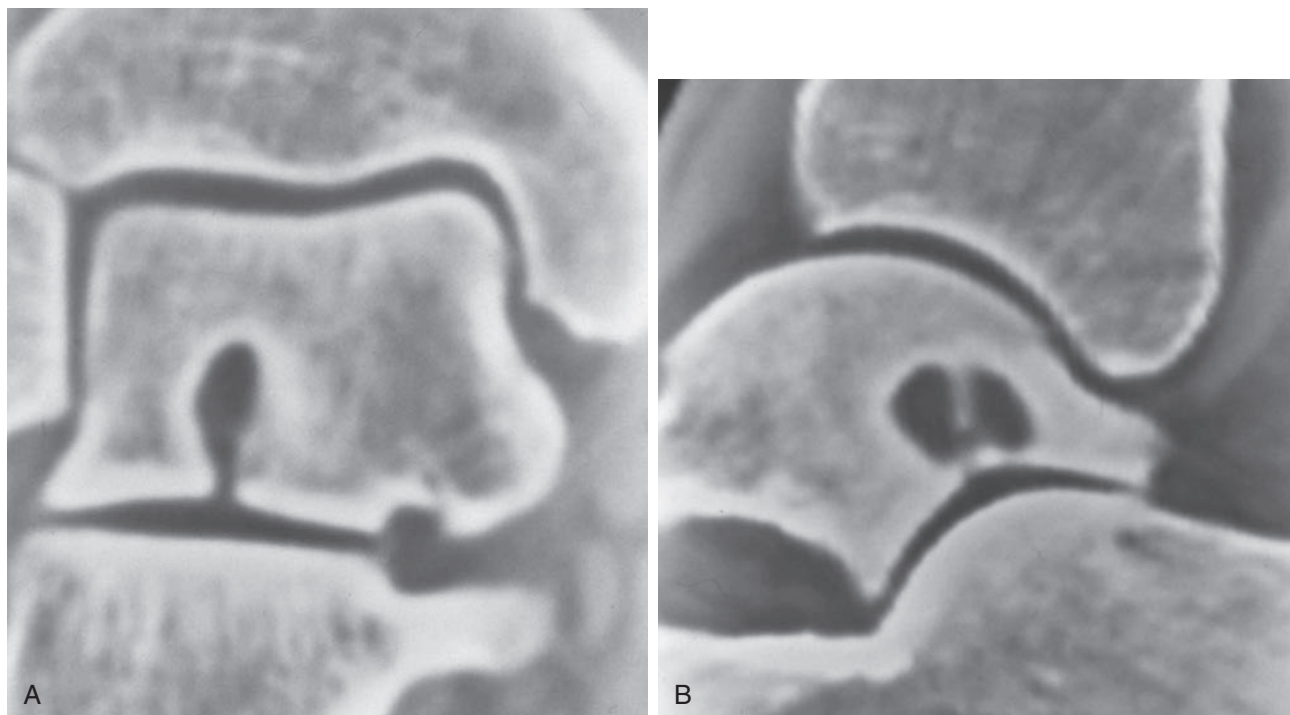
(A and B) A computed tomography (CT) scan is indispensable for proper preoperative planning. This CT scan shows an intraosseous cyst of the right talus that has communication with the subtalar joint.
